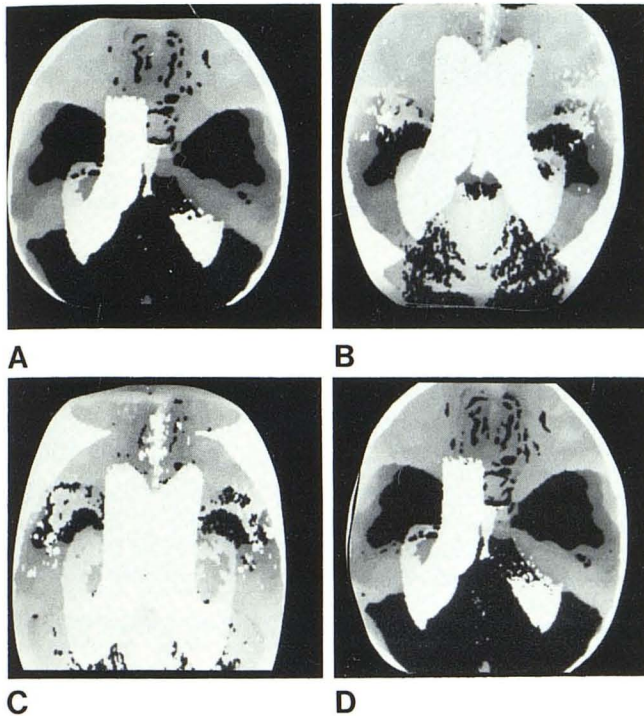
CT cisternogram and ventriculogram after intrathecal administration of metrizamide. Top views of skull with different CT thresholds shown. A, With patient supine, densest (>70 H) part of intraventricular metrizamide has collected in most dependent parts of lateral and third ventricles and in cerebral aqueduct. B, With slightly lower threshold level (34 H), remaining contrast is seen in lateral ventricles, interhemispheric and sylvian fissures, and outlining superior surface of cerebellum. C, Same threshold level with skull mathematically tilted slightly above horizontal axis. D, Same view as A, but higher threshold (75 H).
